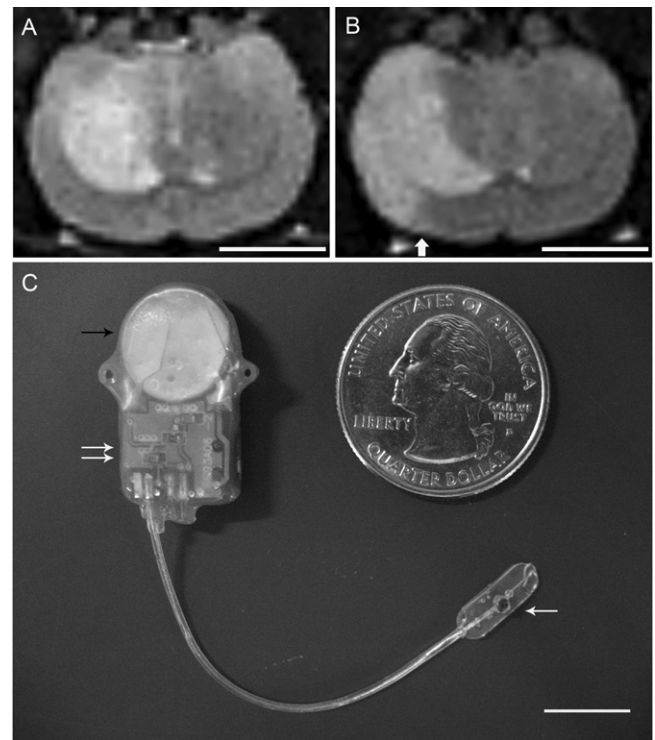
Representative T_2 -weighted MR images and fully implantable device. There were two lesion types on T_2 -weighted MRI after 120 min of MCAO. (A) Lesion restricted to the caudoputamen which was the type excluded in the experiment. Scale bar: 7.5 mm. (B) Lesion additionally involving the cortex which was the type chosen for the experiment. White arrow shows the location of the electrode. Scale bar: 7.5 mm. (C) A fully implantable device consists of a stimulator (double white arrows) and a pair of electrodes. The black arrow represents a lithium cell and the white arrow represents a stimulating platinum electrode ($d=1.5$ mm). Scale bar: 10 mm.
